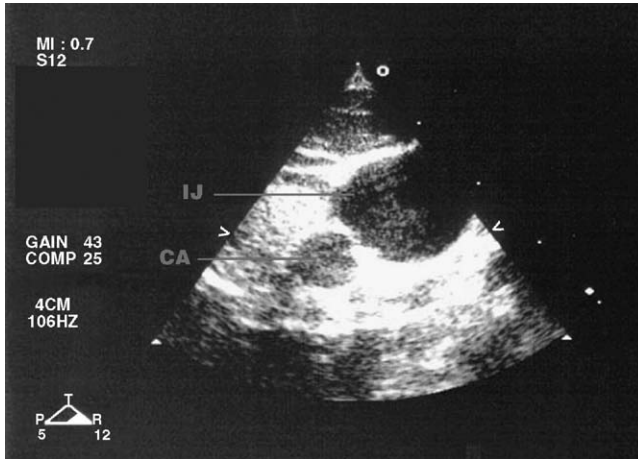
Short axis two-dimensional ultrasonogram of the neck at the level of the cricoid. Probe is in the sagittal plane. IJ, internal jugular vein; CA, carotid artery.
